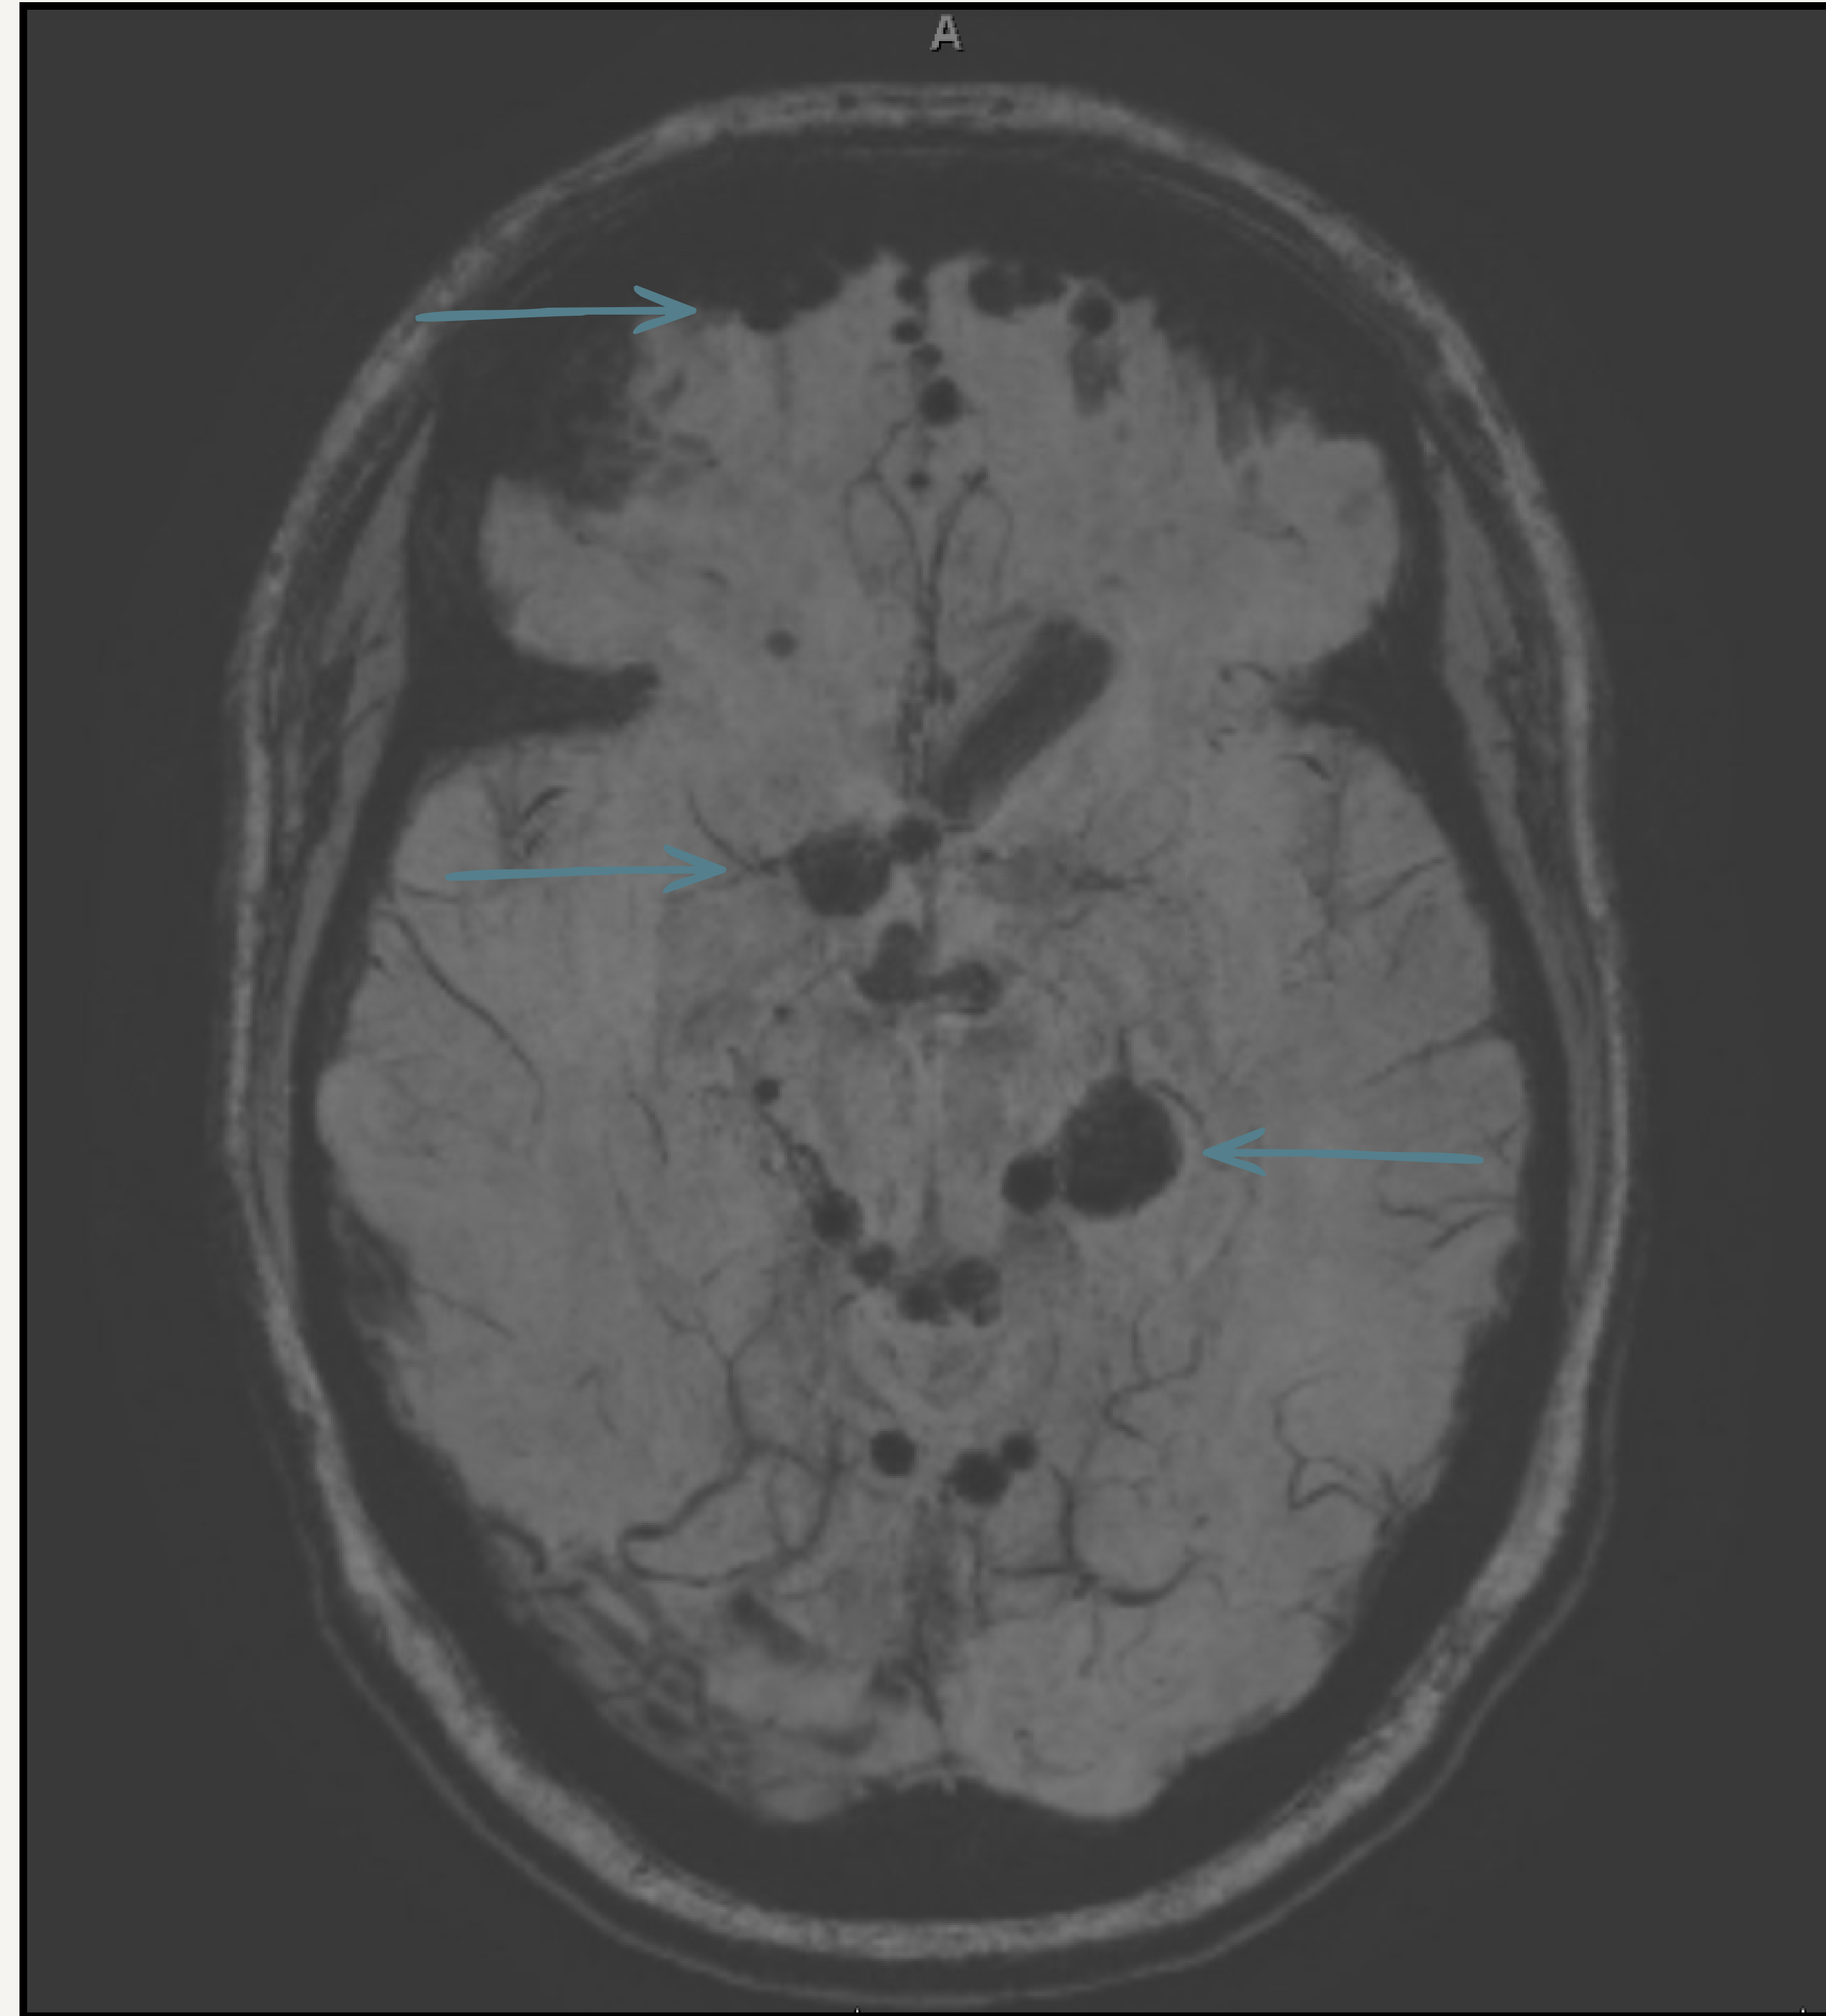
T2 MRI imaging with moderate to large volume pneumocephalus seen after epidural blood patch. Air (arrows) predominately in left greater than right lateral ventricle frontal horns, along the bifrontal CSF spaces, as well as tracking into the basal cisterns and to a lesser extent the cerebellar CSF spaces (not shown).
